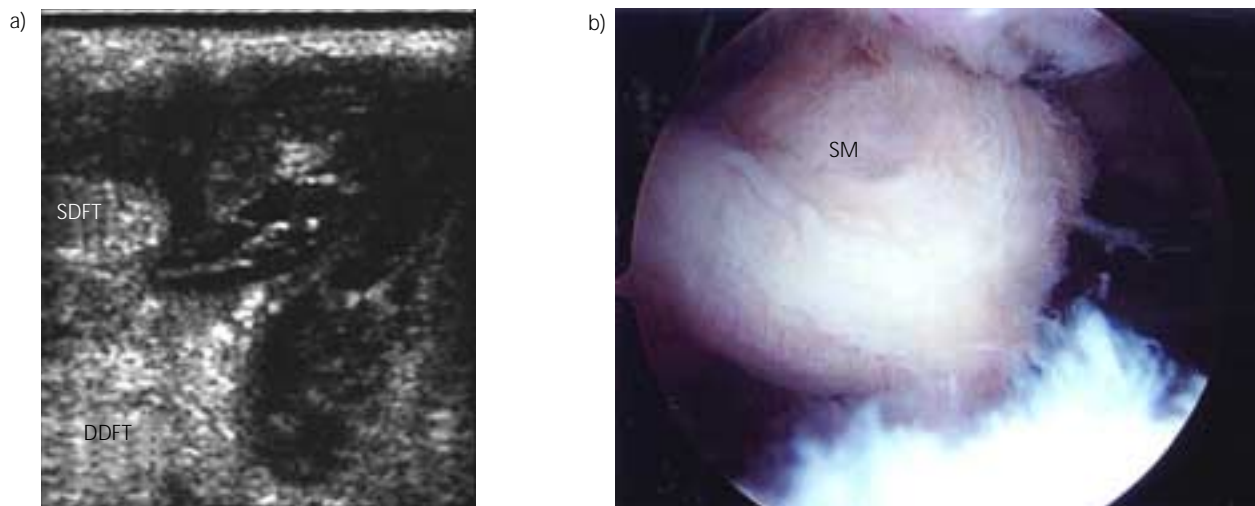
a) Transverse ultrasonographic image of the proximal, palmarolateral digital sheath. Note the presence of echogenic tissue occupying the majority of the digital sheath. It is not apparent whether the tissue (masses) originates from the superficial digital flexor tendon (SDFT), deep digital flexor tendon (DDFT) or the digital sheath. b) An intraoperative image of the synovial mass (SM).
